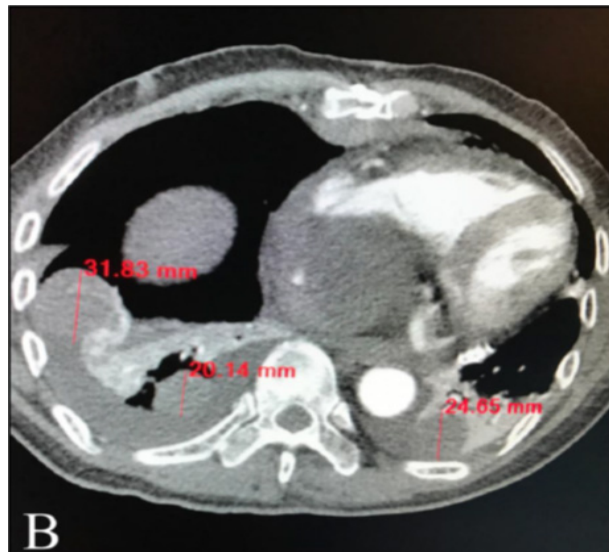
CT scan of the chest post-debulking revealed are two fairly demarcated, non-calcified, mildly enhancing, homogenous, oval densities in the right lower lobe. The largest is located in the lateral segment measuring 32.0 mm and the smaller in the posterobasal segment measuring 20.0 mm. An oval nodule of similar characteristic in the posterobasal segment of the left lower lobe is also seen approximately measuring 25.0 mm. Likewise seen is the atrial mass as described.
